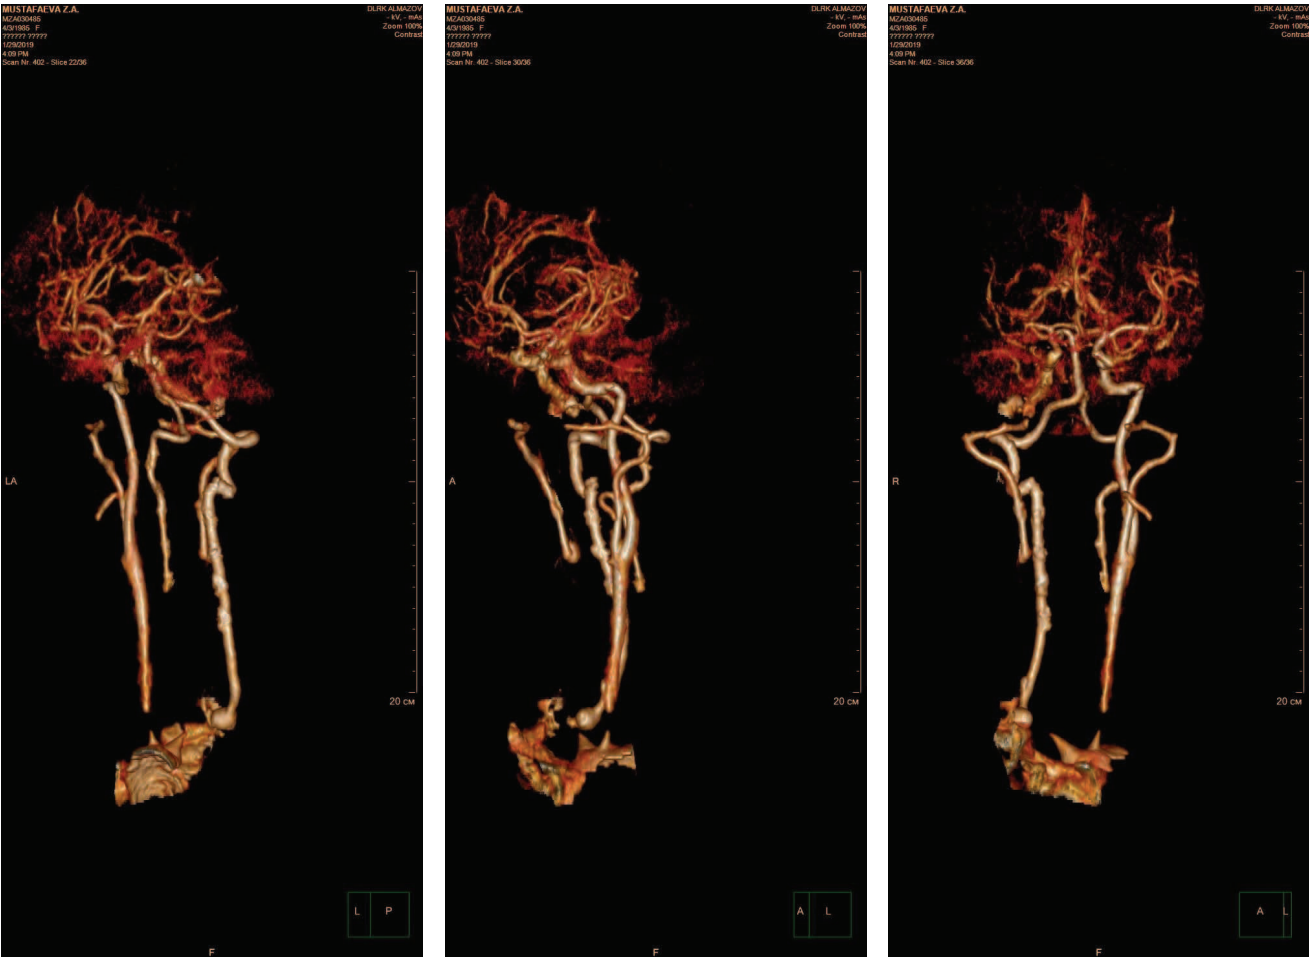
Multislice computed tomography. Thickening of the walls of the aorta and the main arteries of the neck in the proximal sections, occlusion of the right common carotid artery, stenosis of the left common carotid artery
